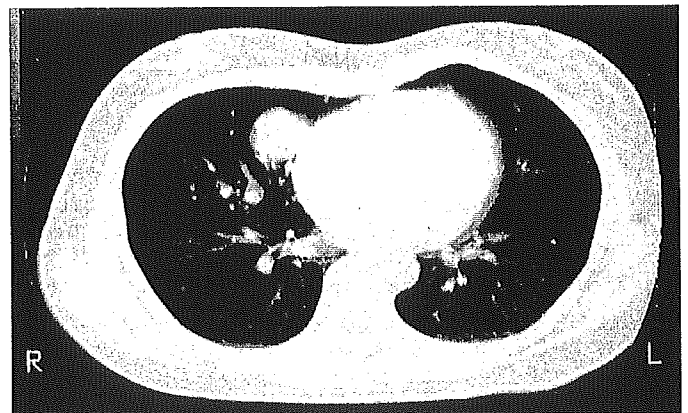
Preoperative CT scans shows the largest nodule, measuring 3.1 cm × 2.9 cm in size, accompanied by numerous tiny nodules in the right middle lobe of the lung.
